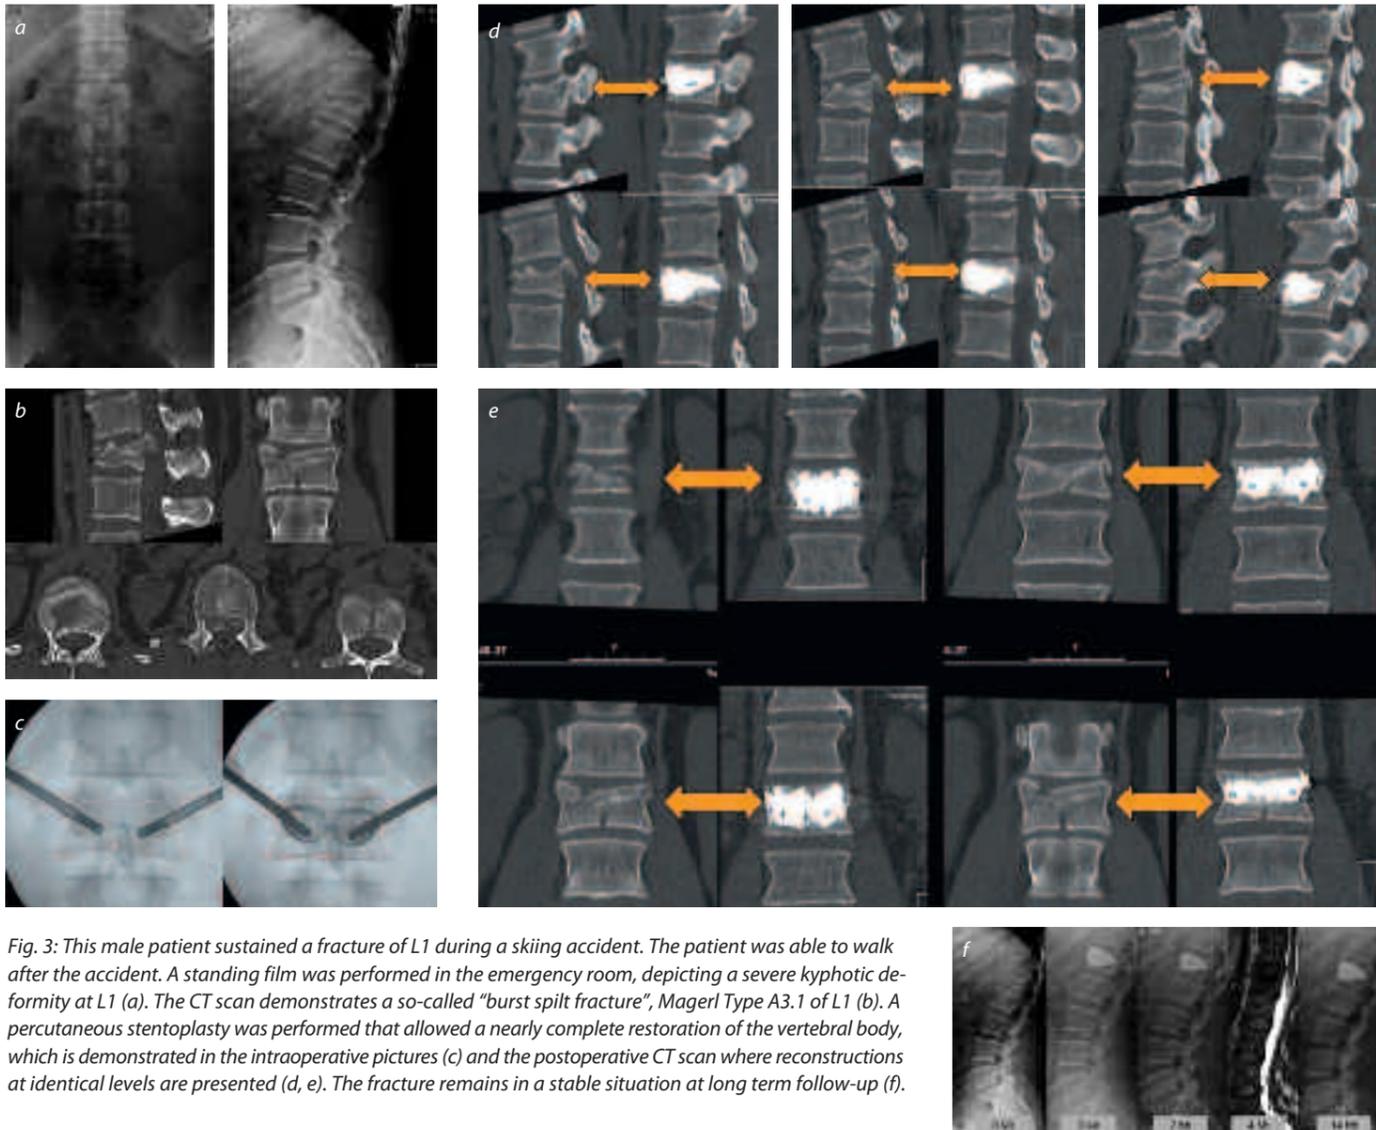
This male patient sustained a fracture of L1 during a skiing accident. The patient was able to walk after the accident. A standing film was performed in the emergency room, depicting a severe kyphotic deformity at L1 (a). The CT scan demonstrates a so-called "burst spilt fracture", Magerl Type A3.1 of L1 (b). A percutaneous stentoplasty was performed that allowed a nearly complete restoration of the vertebral body, which is demonstrated in the intraoperative pictures (c) and the postoperative CT scan where reconstructions at identical levels are presented (d, e). The fracture remains in a stable situation at long term follow-up (f).
